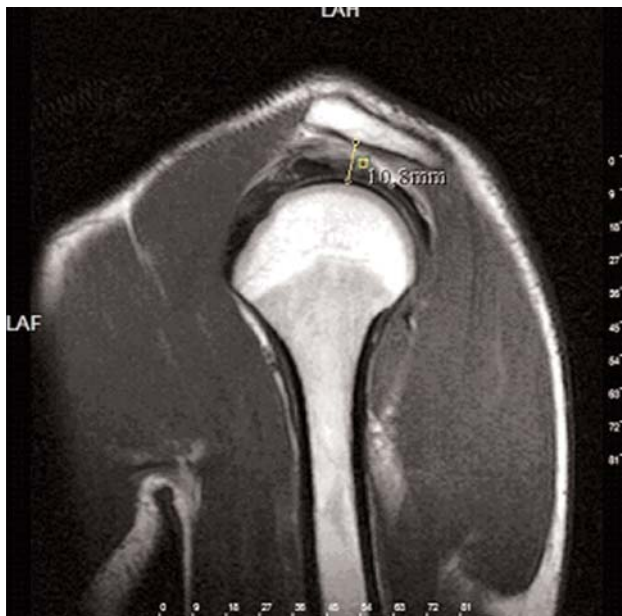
Measurement of the subacromial distance (yellow line) on sagittal T1-weighted image. [Color figure can be viewed in the online issue, which is available at www.aott.org.tr]
